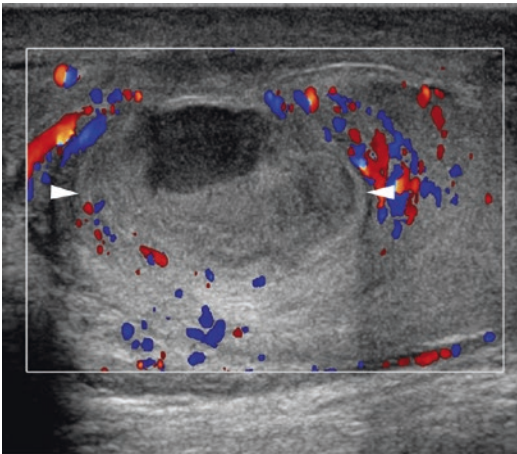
Testicular abscess. Longitudinal scan showing a testicular lesion with mixed echotexture (*arrowheads*) lacking vascularization at color Doppler interrogation
